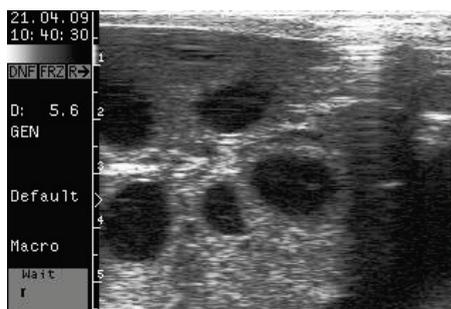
Ultrasound image with superovulated ovary (original)
